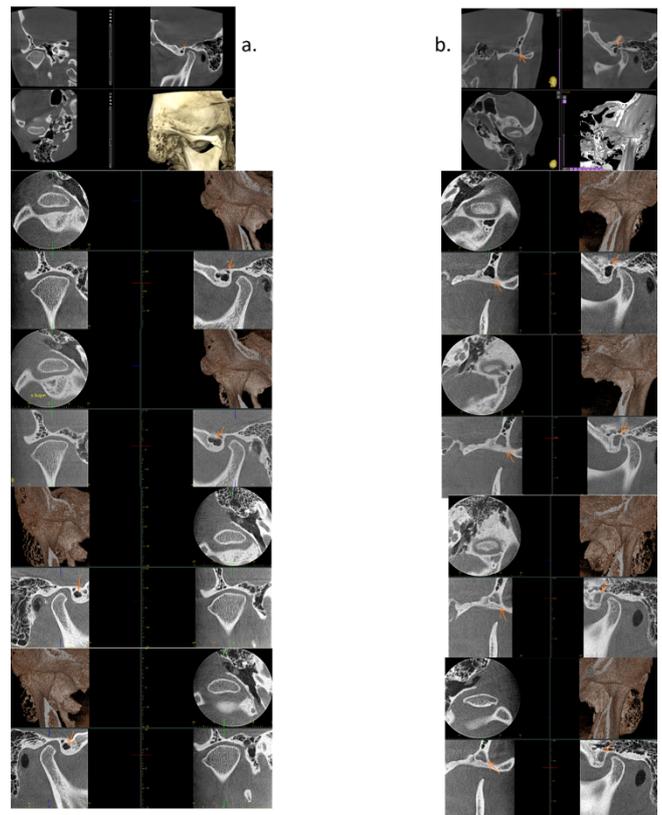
The TMJ CT dynamics. The arrow indicates the area of interest. a. Right TMJ. b. Left TMJ.
